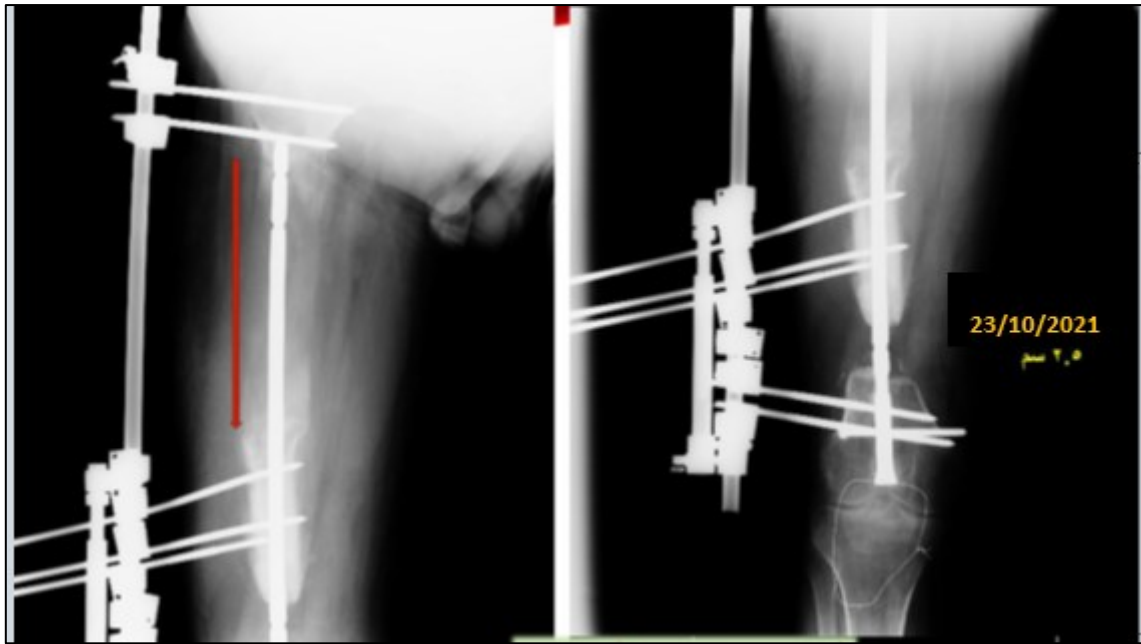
X-ray 6.5 Months Post-Second Surgery
